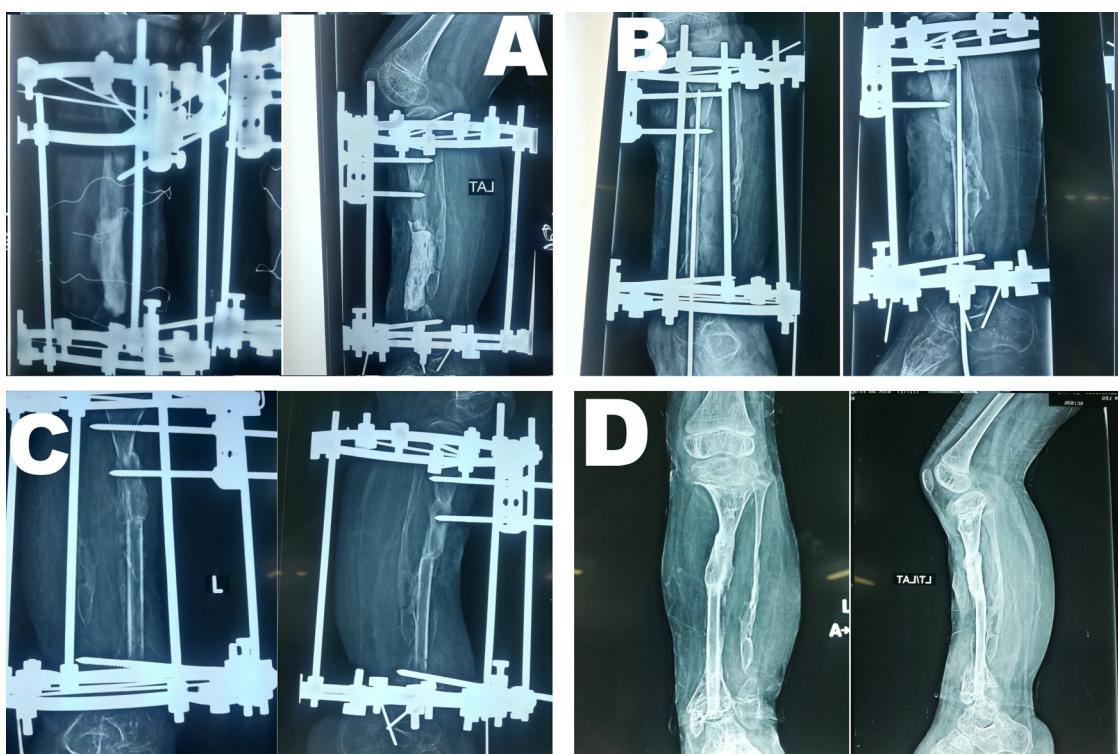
Radiographs showing the technique. A: 1st stage with cement spacer. B: 2nd stage: cancellous iliac and free fibular strut autografts fixed with K-wire. C: Wire removal to allow ankle motion. D: Anteroposterior and lateral views showing sound union.
